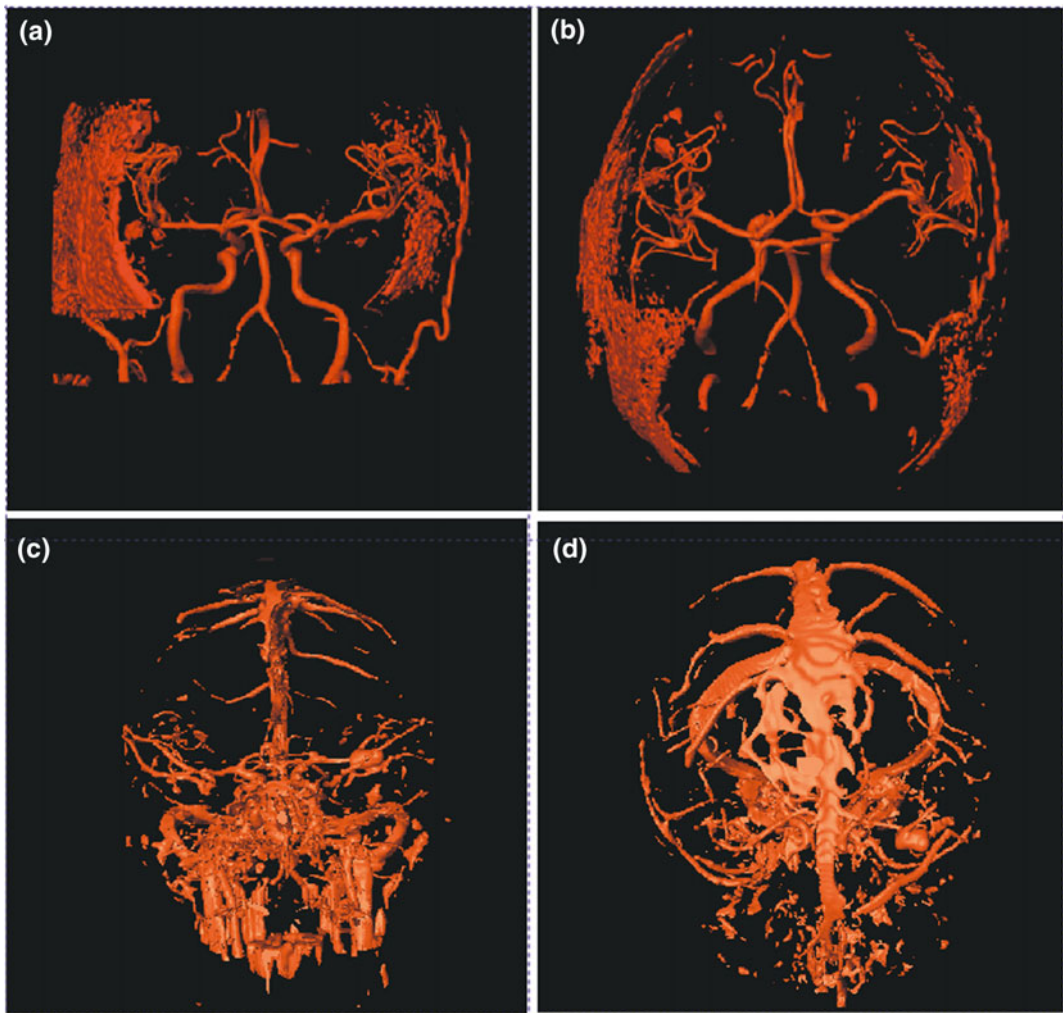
Comparison of MRA and CTA models after volume segmentation. The anterior view (a) and superior view (b) of MRA models using the volume segmentation method. The cerebrovasculature appears smooth and identifiable, and has only a small amount of other tissues (cancellous bony structures) remaining in the MRA
